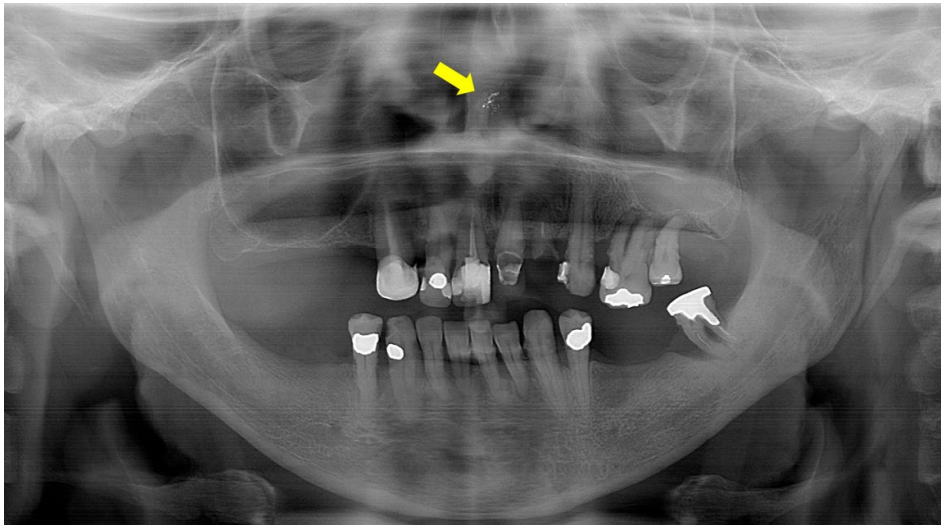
Panoramic radiograph shows multiple punctiform radiopaque images over the left nasal fossa near the nasal septum.
